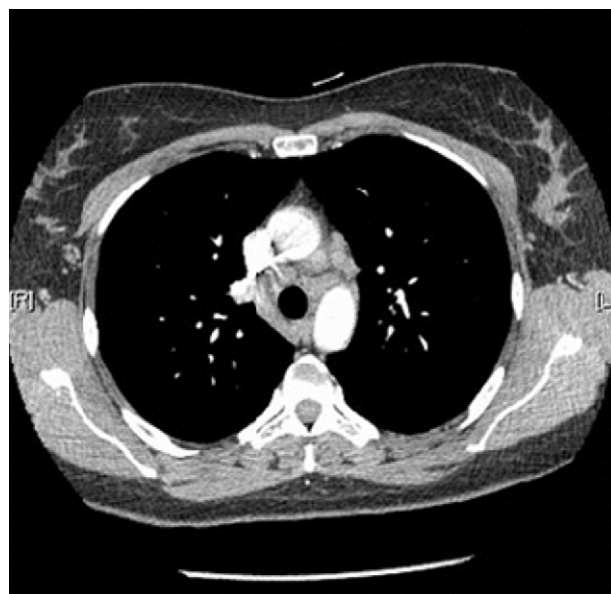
Chest CT: hilar and mediastinal lymphadenopathy (grade 1 sarcoidosis).
